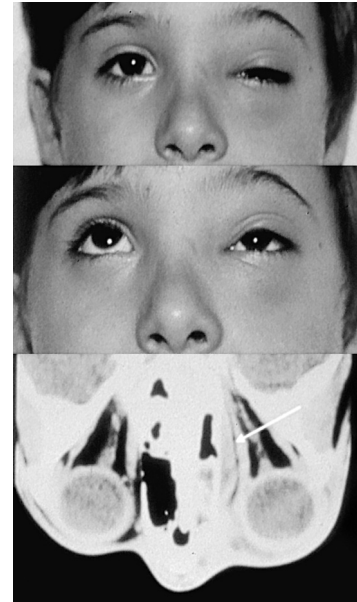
A subperiosteal abscess of the left orbit (top image). Note the limitation of upward movement of the left eye (middle image). The computed tomographic scan shows ethmoid sinusitis and a subperiosteal abscess bowing the left medial rectus muscle laterally (bottom image; arrow).
